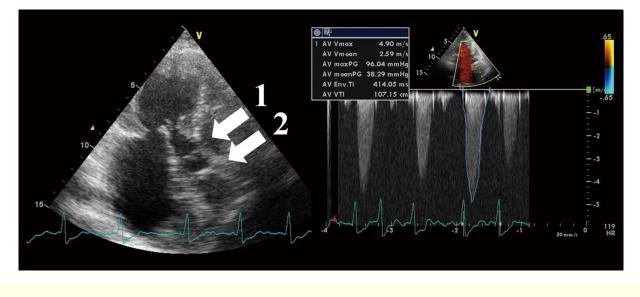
Transthoracic echocardiography indicated a tri-leaflet aortic valve with good opening of the leaflets (arrow 1) and a membrane-like structure (arrow 2) with a 94-mmHg peak pressure gradient above the aortic valve.
